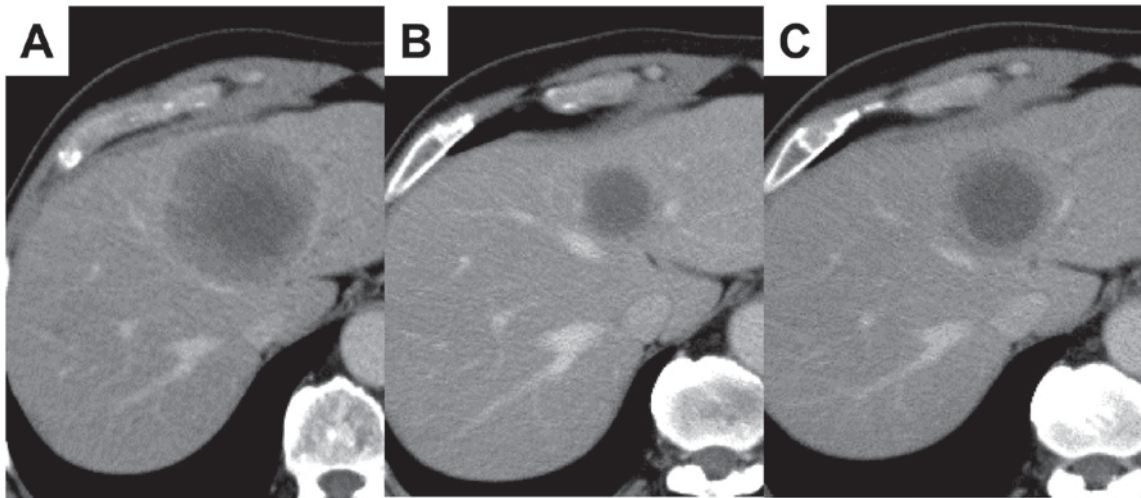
CT scans of liver metastasis. CT scans (A) just before the initiation of CDDP and ETP; (B) after four cycles of CDDP and ETP; and (C) just before the initiation of AMR. CT, computed tomography; CDDP, cisplatin; ETP, etoposide; AMR, amrubicin.
